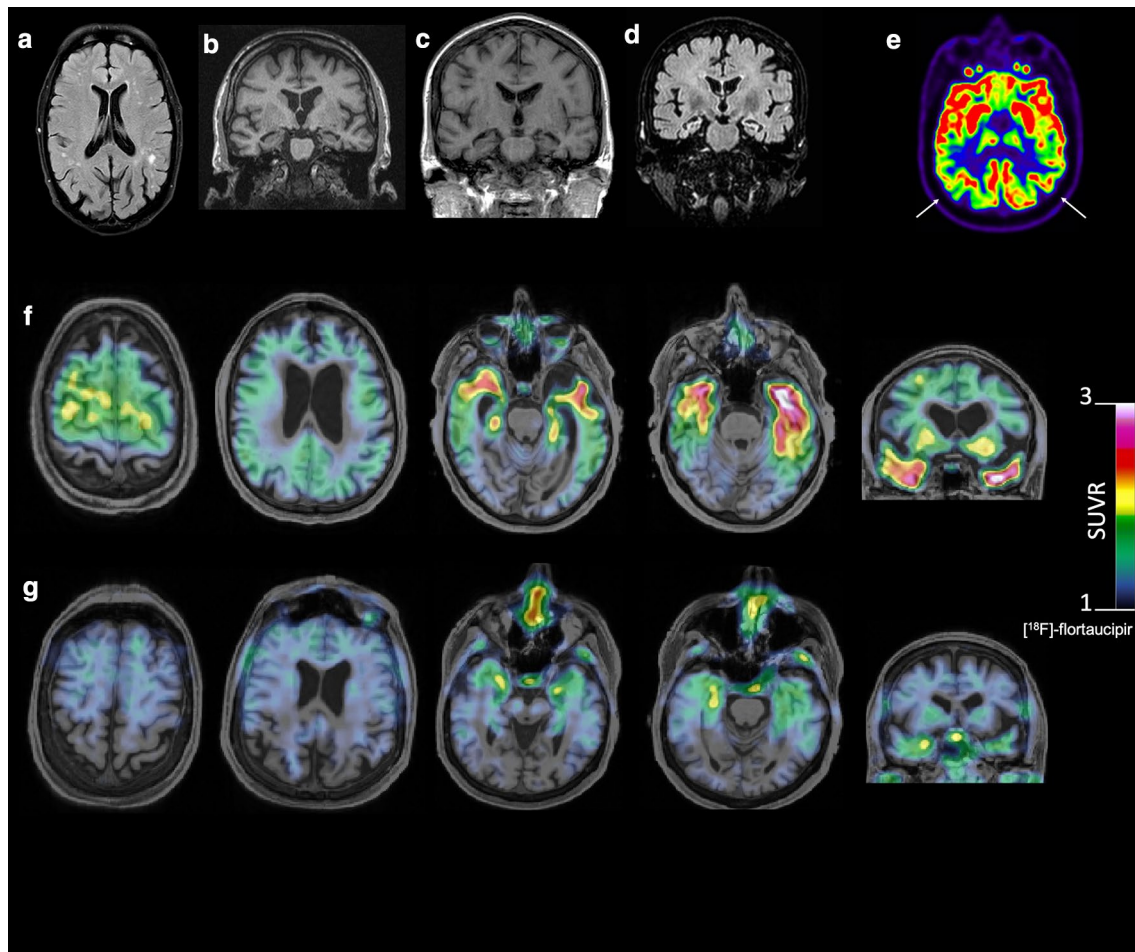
Structural, functional and Tau PET Cerebral imaging of MAPT duplication carriers. a FLAIR-weighted axial MRI scan of EXT_1593_001 showing parietal cortical atrophy and mild white matter hyperintensities. b T1-weighted coronal MRI scan of EXT_1114_001. c T1-weighted coronal MRI scan of ROU_1373_001. d FLAIR-weighted sequence coronal MRI scan
